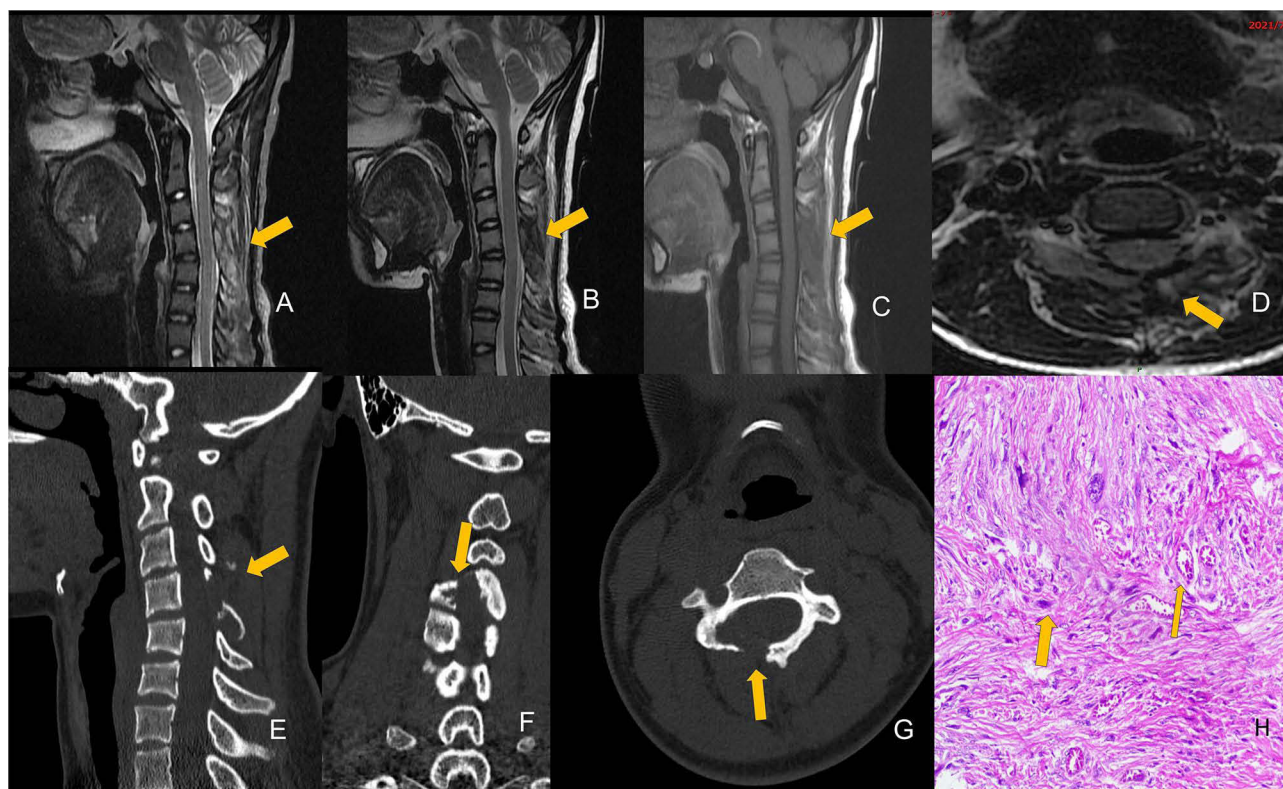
Synovial Sarcoma of the Right Lamina of C4, Female, 15 years old, with neck and shoulder pain accompanied by discomfort in the left upper arm for 2 months. (A) Fat-suppressed T2-weighted imaging (T2WI) sagittal view shows the right lamina of C4 with intermediate and slightly high signal intensity. (B and D) T2WI sagittal and axial views show the lesion with intermediate signal intensity. (C) T1-weighted imaging (T1WI) sagittal view shows the lesion with intermediate signal intensity. (E–G) CT scan without contrast shows the lesion with lytic bone destruction. (H) HE ($\times 20$) shows that tumor cells are spindle-shaped and amorphous (thick arrow), mostly exhibiting degenerative changes, with occasional tumor giant cells (thin arrow) and surrounding dense fibrous tissue hyperplasia.
